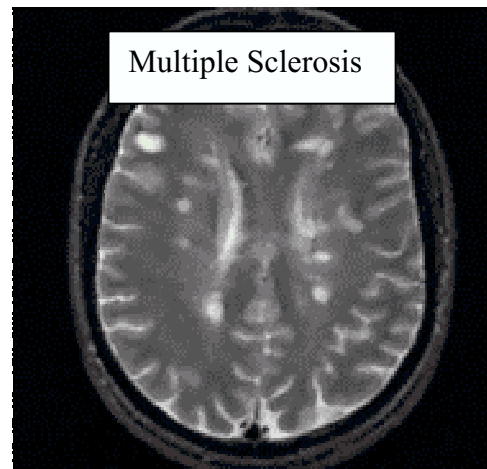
Typical multiple sclerosis image in MRI.
